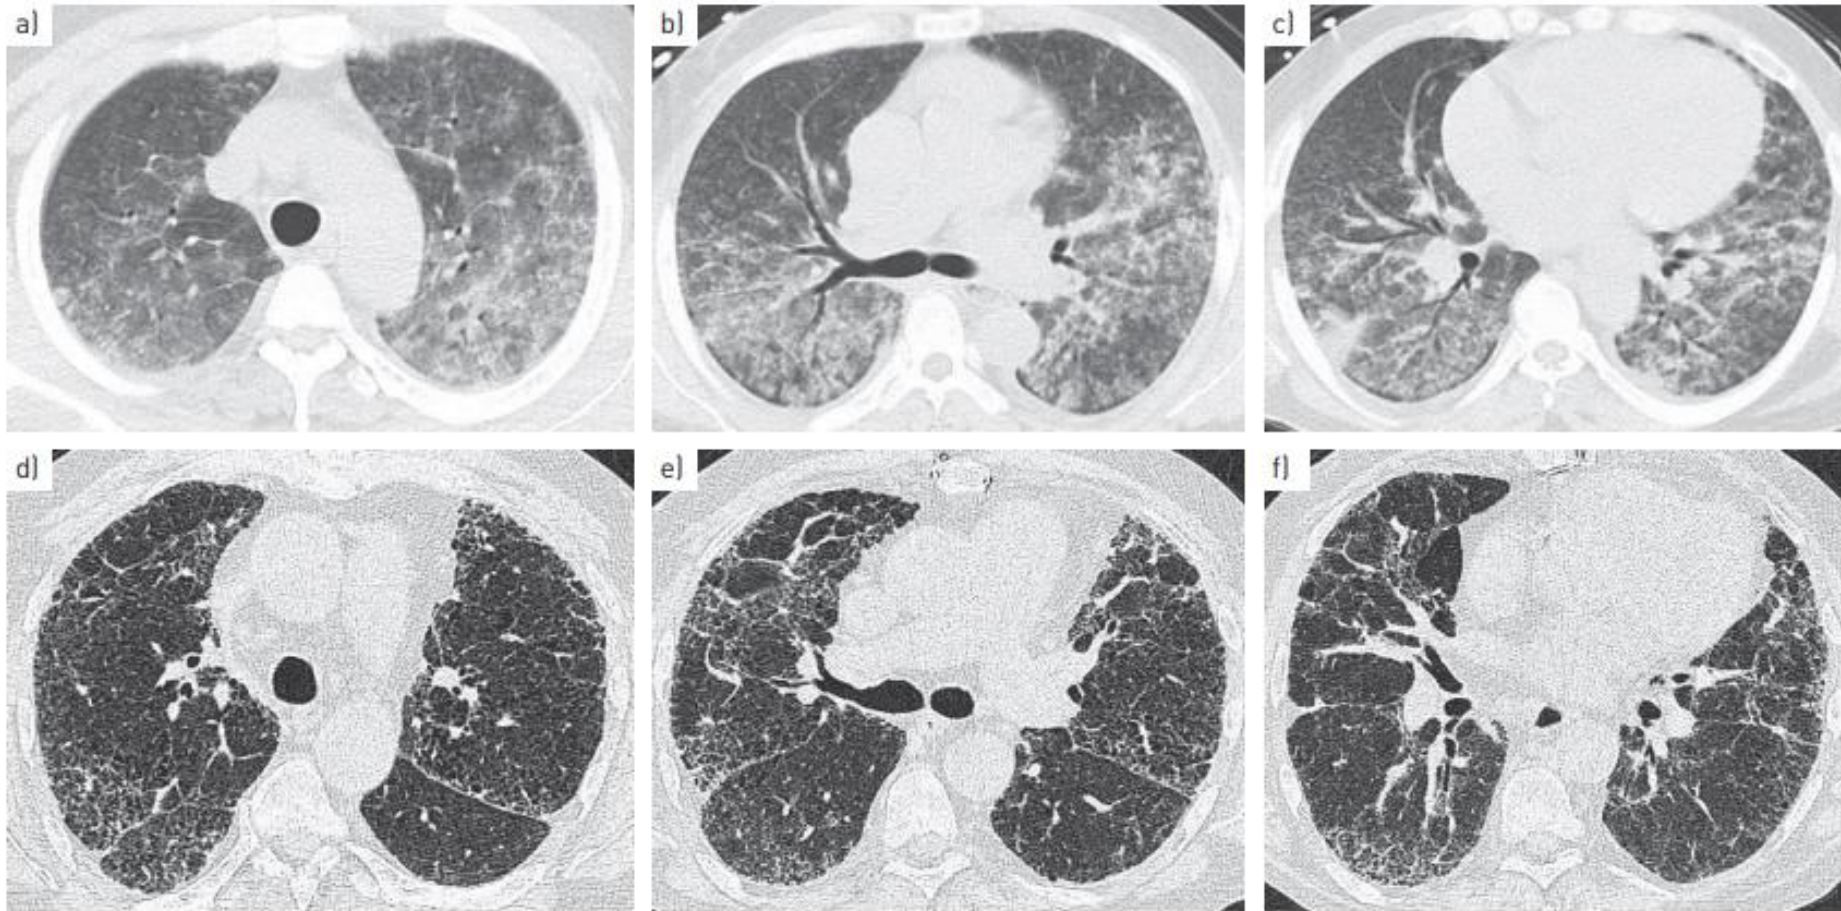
Chest high-resolution computed tomography (HRCT) of a-c) acute hypersensitivity pneumonitis and d-f) chronic hypersensitivity pneumonitis. Chest HRCT of acute hypersensitivity pneumonitis shows bilateral ground-glass densities with centrilobular micronodular accentuation and minor consolidation. Chest HRCT of chronic hypersensitivity pneumonitis shows bilateral reticular shadowing, traction bronchiectasis and minor mosaic perfusion along with some micronodules.
